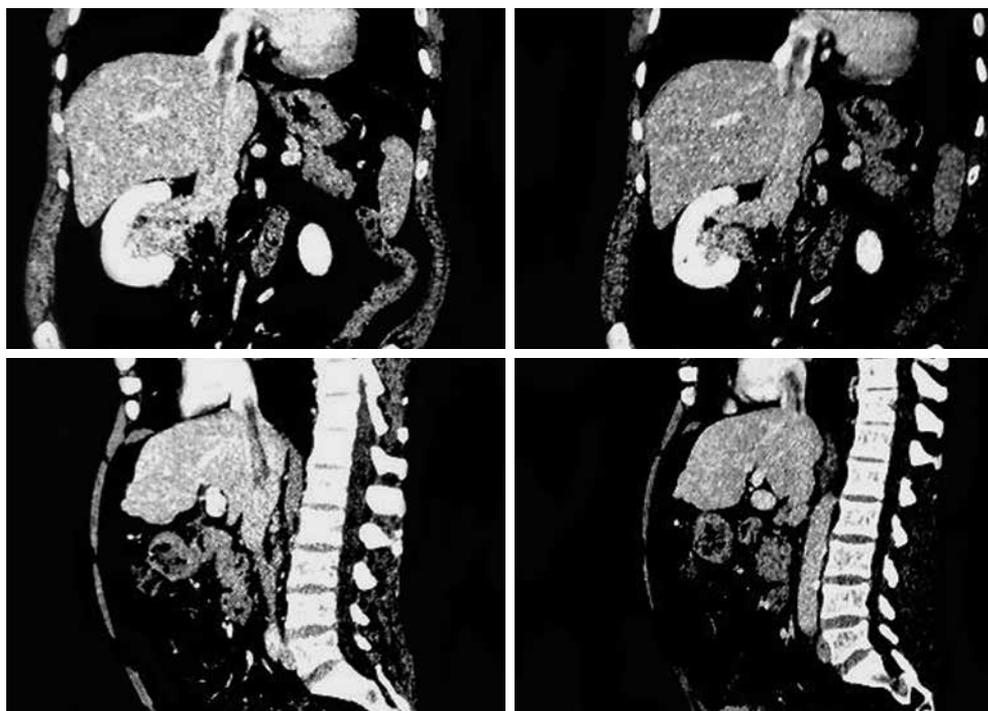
A computed tomography image of a hypodense thrombus in the left renal vein extending into the inferior vena cava and right atrium low attenuation.
